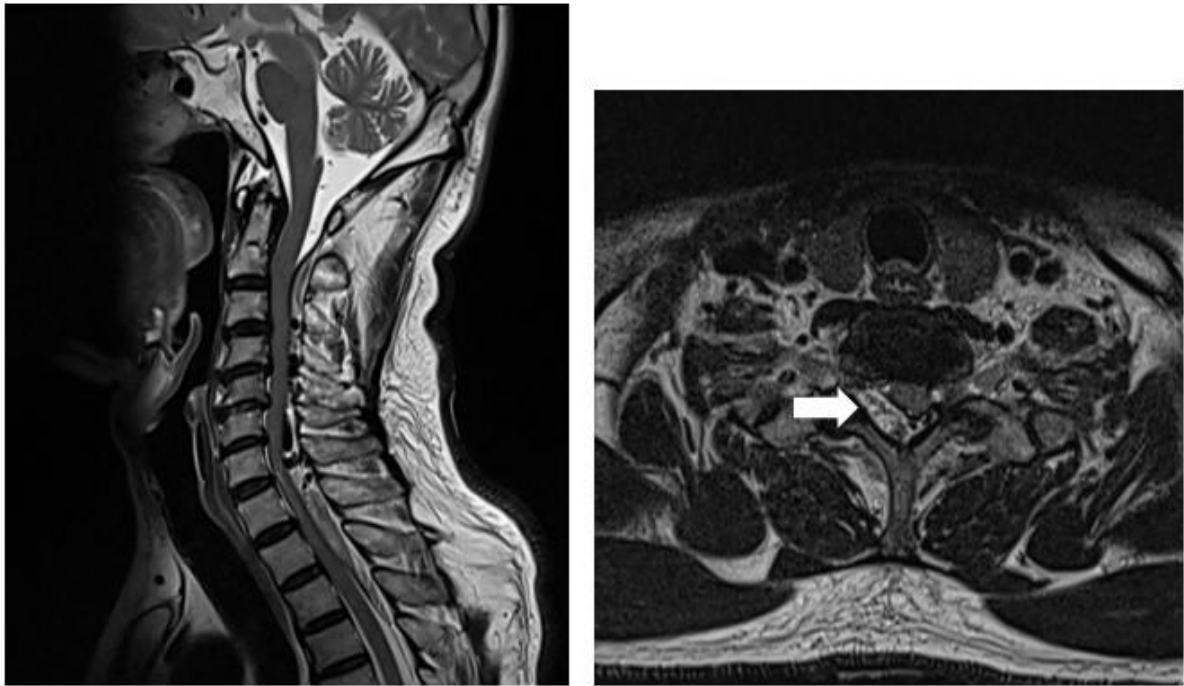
C-spine MRI taken after quadriplegia. A parasagittal T2-weighted image and an axial T2-weighted image at the level of C7/T1. MRI images show epidural hematoma with air bubbles in C2~T4 posterior epidural space. White arrow indicates the externally injected autologous blood may be the cause of cord impingement or compression, C2-3~T2-3.
